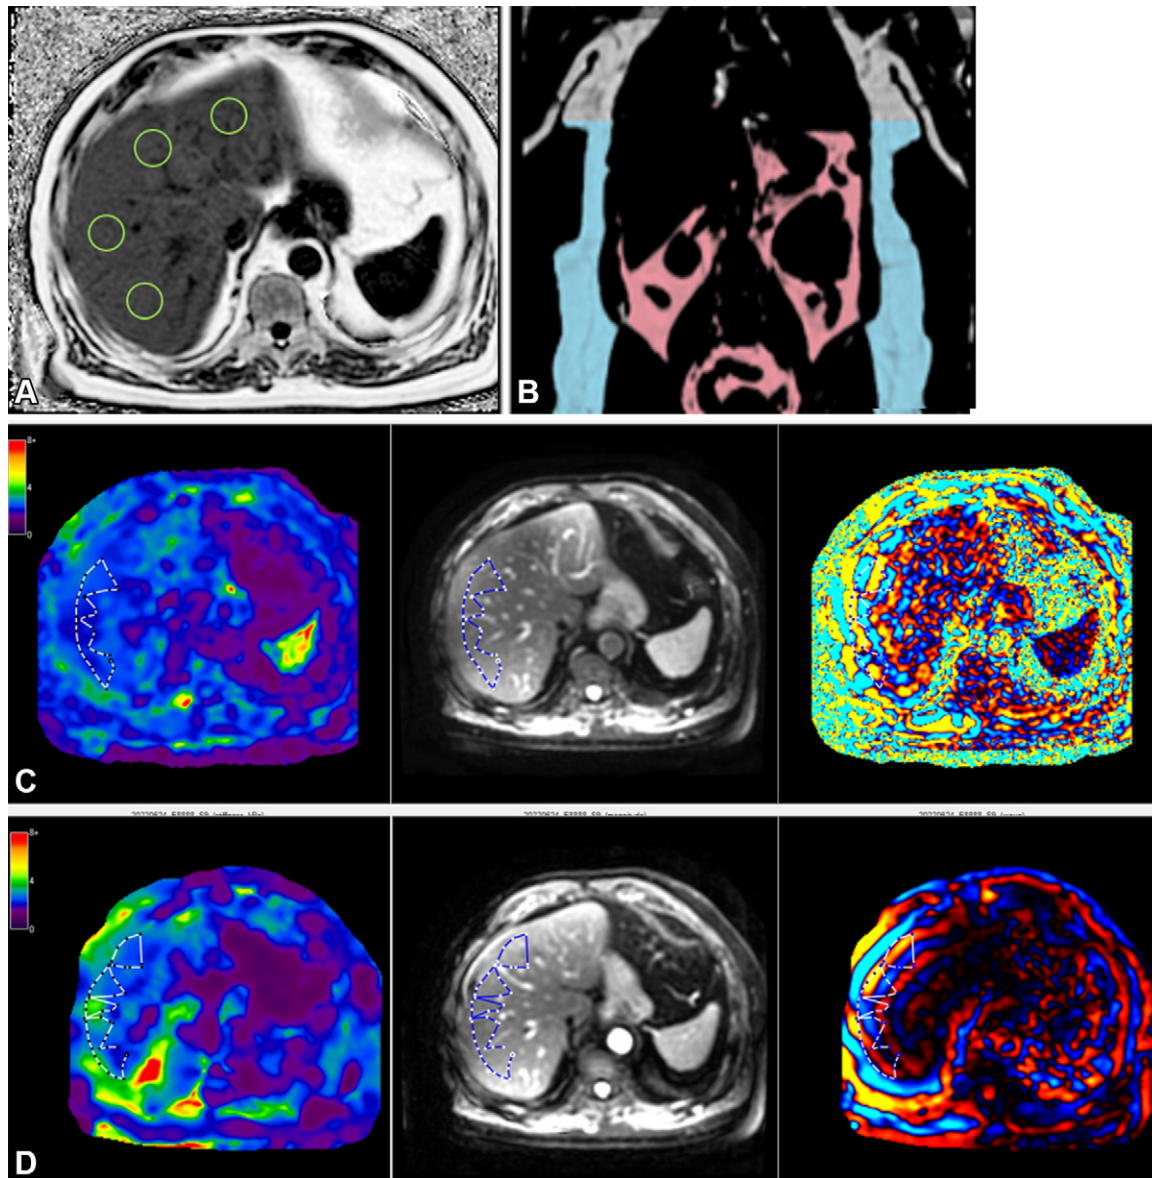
MRI in a 65-year-old male participant with low likelihood of advanced fibrosis according to the fibrosis based on four factors (FIB-4) index. (A) Axial MRI proton density fat fraction map shows regions of interest (green circles) drawn in each Couinaud segment while avoiding any vessels or lesions, as per the study protocol. (B) Coronal image shows body composition with autosegmented visceral (pink) and subcutaneous (blue) adipose tissue. (C) Left to right: Axial elastogram, magnitude, and wave images obtained at two-dimensional MR elastography (MRE) show placement of the region of interest (dotted outline) in the region of parallel wave propagation, avoiding the outer edge of the liver. (D) Left to right: Axial elastogram, magnitude, and wave images obtained at three-dimensional MRE similarly show the region of interest (dotted outline) in a region of parallel wave propagation, avoiding the outer margin of the liver. Color bars alongside elastograms indicate a range of kilopascals from low (purple) to high (red).
